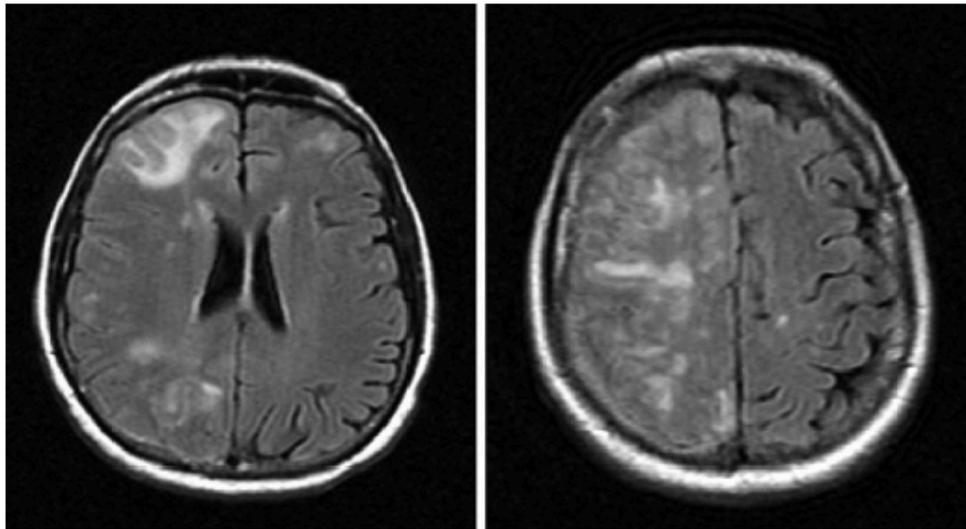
ARIA-E which occurred during a monoclonal antibody trial, as seen on fluid attenuation inversion recovery (FLAIR) magnetic resonance images demonstrating increased signal in multiple regions of the right hemisphere affecting both gray and white matter.
